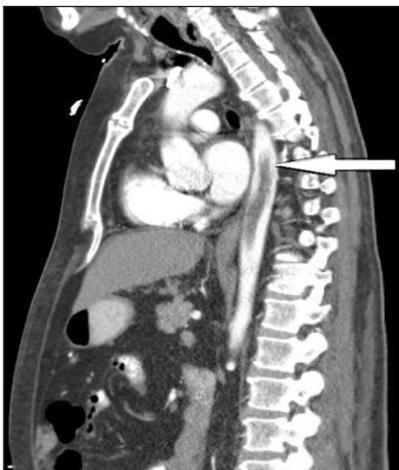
Sagittal-view computed tomography image of the patient's chest. The white arrow indicates the large aortic thrombus originating at the left subclavian artery.
